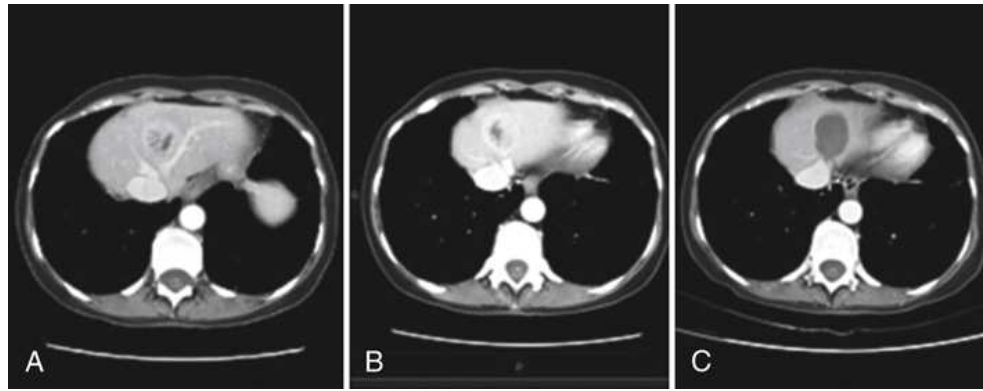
Low-dose axial CT images from radiofrequency ablation study. Scans are before study (A), during study (B), and after study (C). Courtesy Philips Medical Systems.
